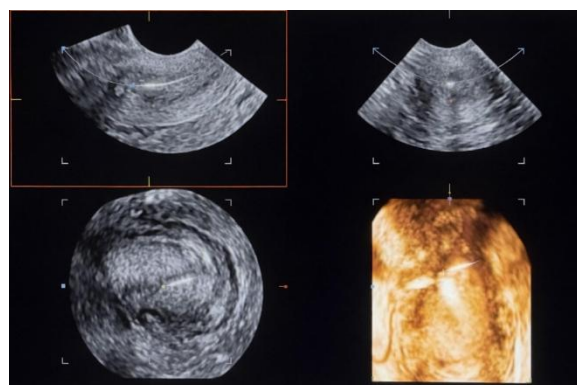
Ultrasound image of an embedded IUCD (Cu T 380A)
